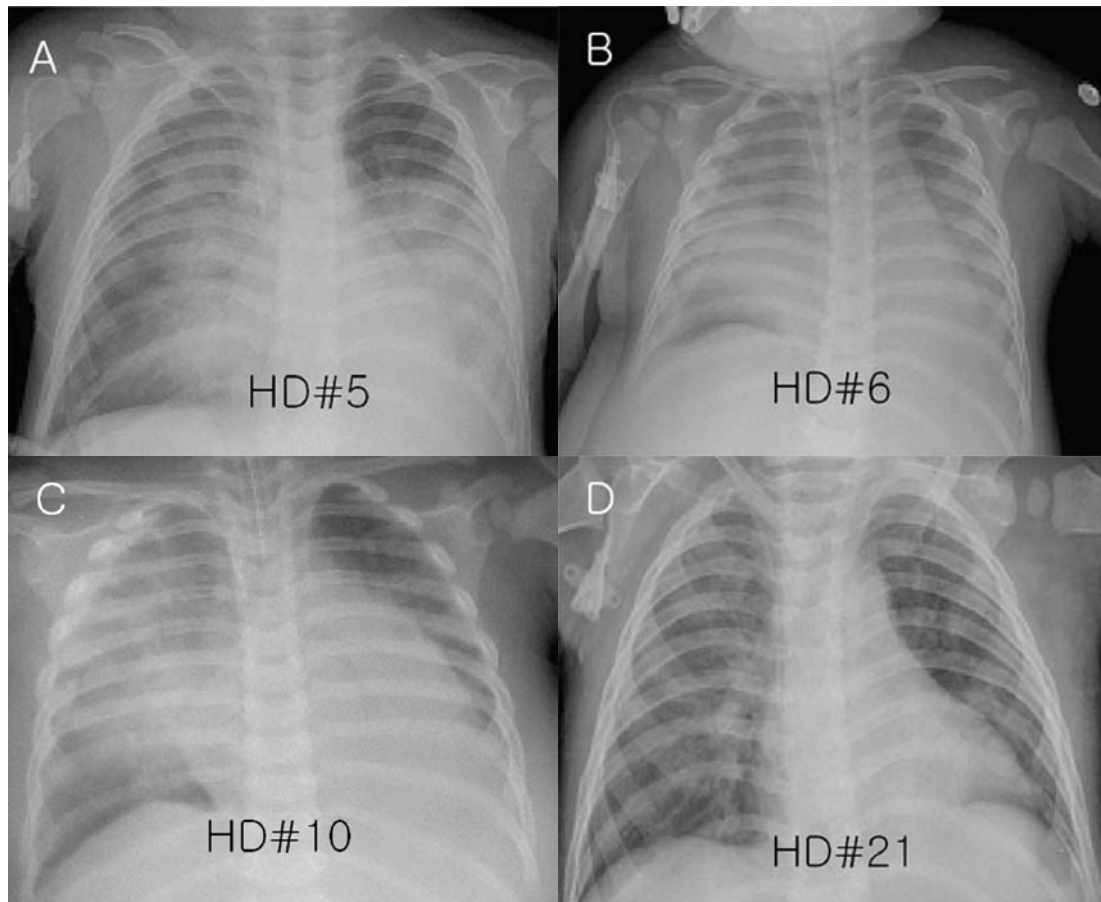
Serial chest x-rays. (A) A diffuse opacification of both lung fields showing ARDS following pulmonary hemorrhage. (B) An improvement in bilateral haziness. (C) Cardiomegaly (CT ratio 0.64) and pulmonary congestion in dilated cardiomyopathy. (D) An improvement of a chest film along with recovery of cardiopulmonary and general conditions.
